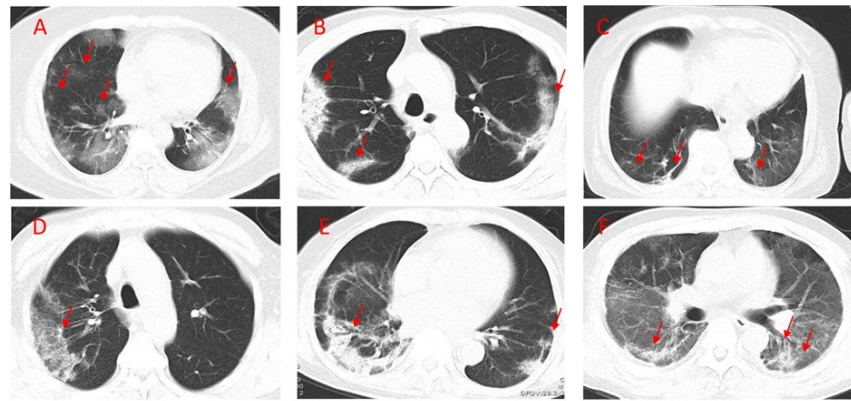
Representative chest CT images in several COVID-19 patients. (A) 58-year-old female, day 14 after symptom onset: bilateral multi-focal ground-glass and nodules in the right upper lobe; (B) 81-year-old man, day 12 after symptom onset: bilateral predominant consolidation pattern, mainly located in the subpleural area, parallel to the pleura like a ribbon; (C) 78-year-old woman, day 13 after symptom onset: ground-glass opacities in bilateral lower lobe with fibrous lesions in the right lower lobe; (D) 78-year-old man, day 19 after symptom onset: ground-glass opacity, crazy-paving pattern and in the right lobe, mainly located below the pleura; (E) 82-year-old woman, day 20 after symptom onset: bilateral and subpleural predominant consolidation pattern, runs along the pleura in a parallel shape with air bronchograms in the right lobe; (F) 47-year-old man, day 34 after symptom onset: bilateral white lung with ground-glass opacities.
